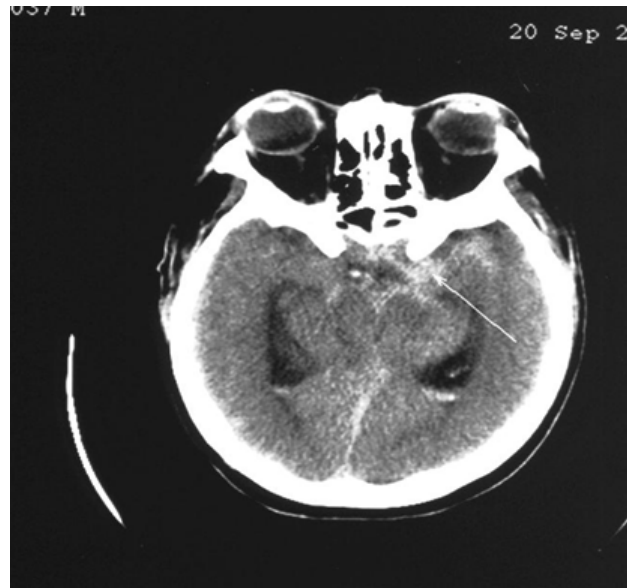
Simple, non-contrasting brain CT. SAH foundation tanks (white arrow), complicated intraventricular hemorrhage (blue arrow).
